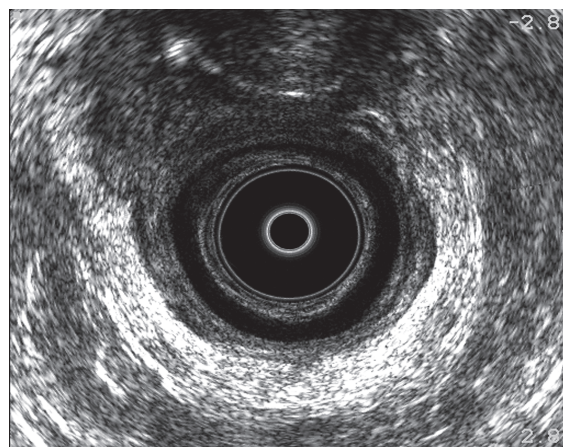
Endoanal ultrasound demonstrating intact internal and external anal sphincter
